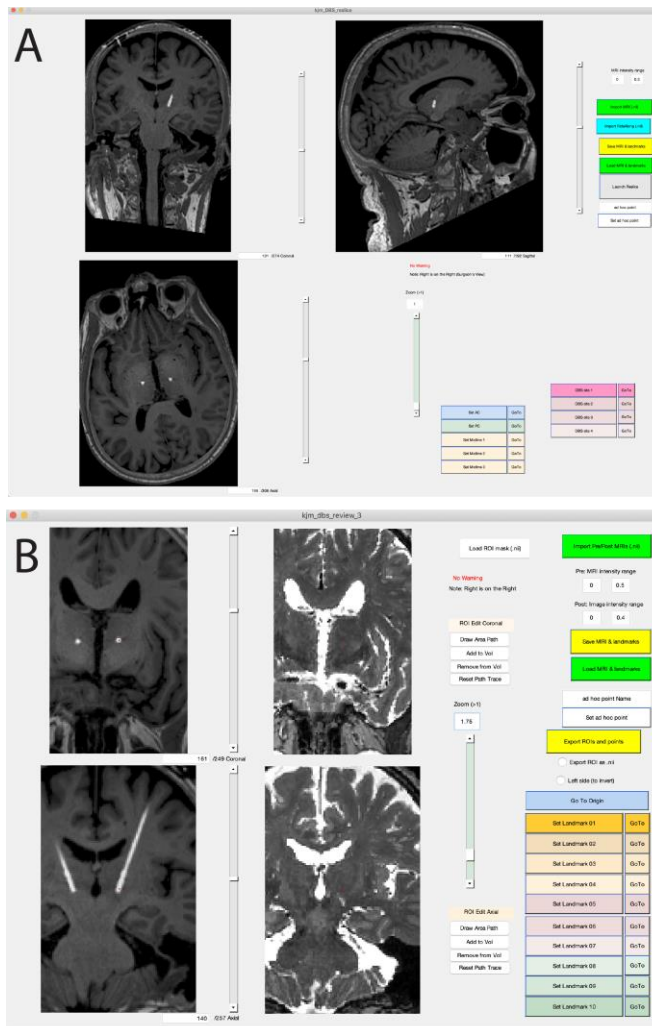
Visualizing an STN DBS lead with our in-plane, mirror-symmetric visualization tool. (A) The DBS Reslicing GUI presents three orthogonal views of the fused CT-MRI. The brain has not yet been rotated and only a small fragment of the DBS lead can be seen. The user selects points along the DBS lead and along the mid-sagittal plane to enable the necessary rotations (see IIB). The rotated fused image and ride along images are output in NIFTI format. (B) The DBS Review GUI displays the resulting fused image with the right DBS lead in-plane. The T2 MRI was included as a ride along image, receiving the same rotations. Further segmentation of anatomic structures is possible with this GUI.
